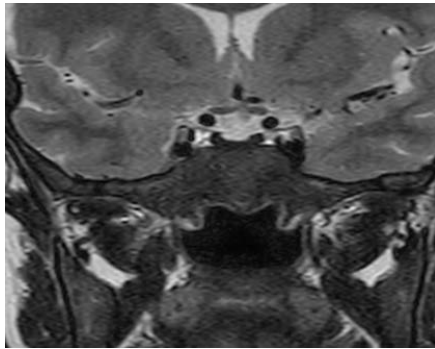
Pituitary MRI: Hemochromatosis of the pituitary gland (Case 1)
